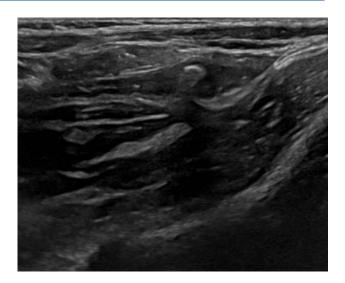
An abdominal ultrasound revealed an echogenic structure at the tip of the appendix, with the posterior acoustic shadowing measuring approximately 5 mm. This was initially misinterpreted radiologically as an appendicolith but was later identified as E. vermicularis.
